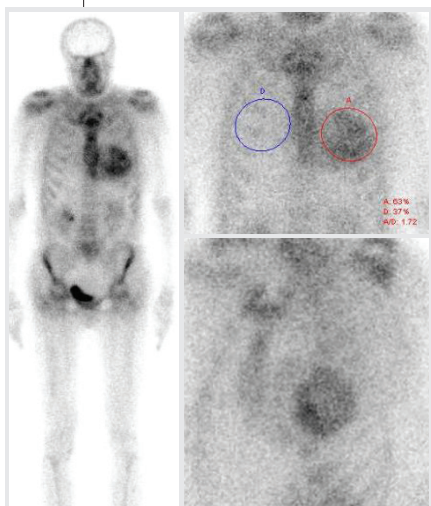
Transthyretin-related cardiac amyloidosis. The planar ^{99m}Tc-Pyrophosphate scintigraphy (whole body, anterior and left oblique images) showing diffusely intense myocardial activity, greater than in ribs and sternum; regions of interest drawn over the myocardium and the contralateral side show heart/contralateral uptake ratio of 1.72.
